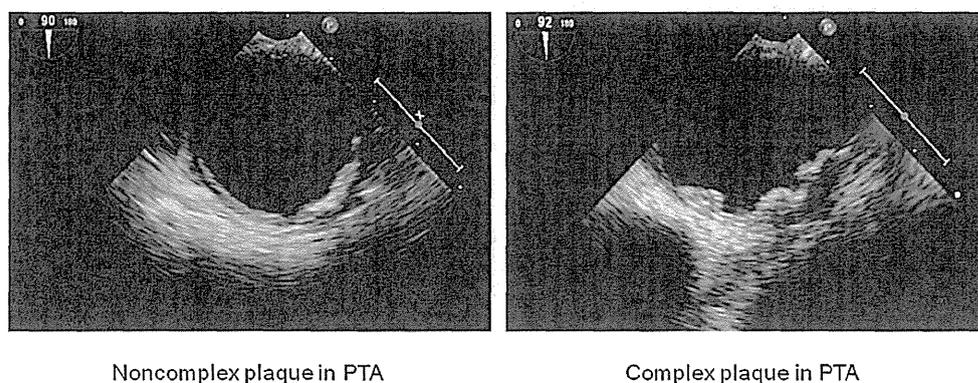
Example images of noncomplex and complex aortic plaques detected using transesophageal echocardiography. PTA indicates proximal thoracic aorta.
